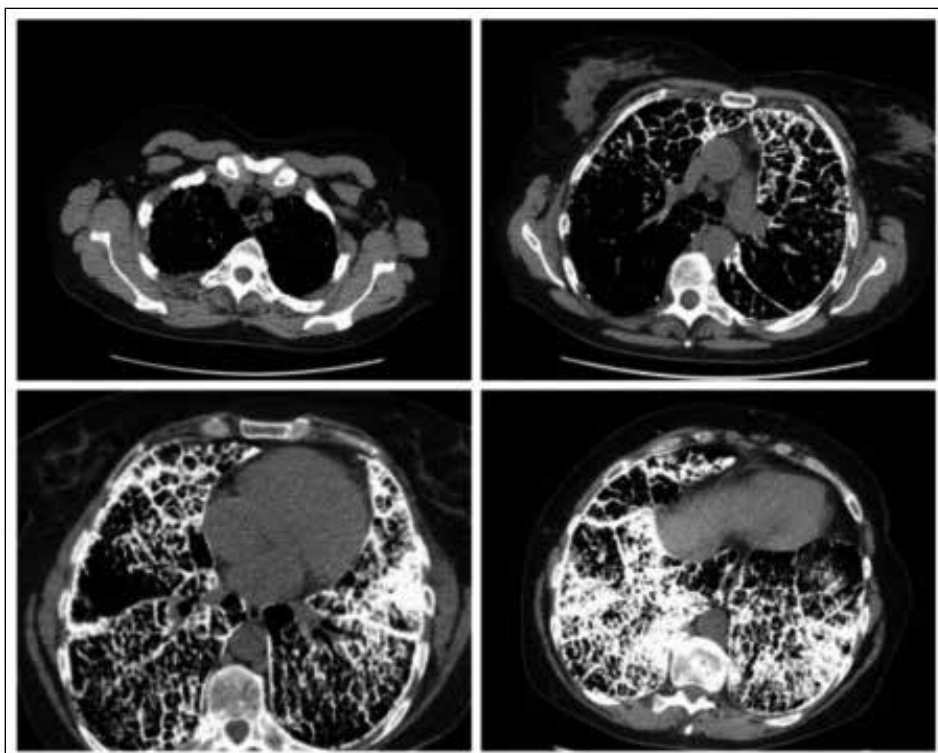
Chest CT- the mediastinal window.
